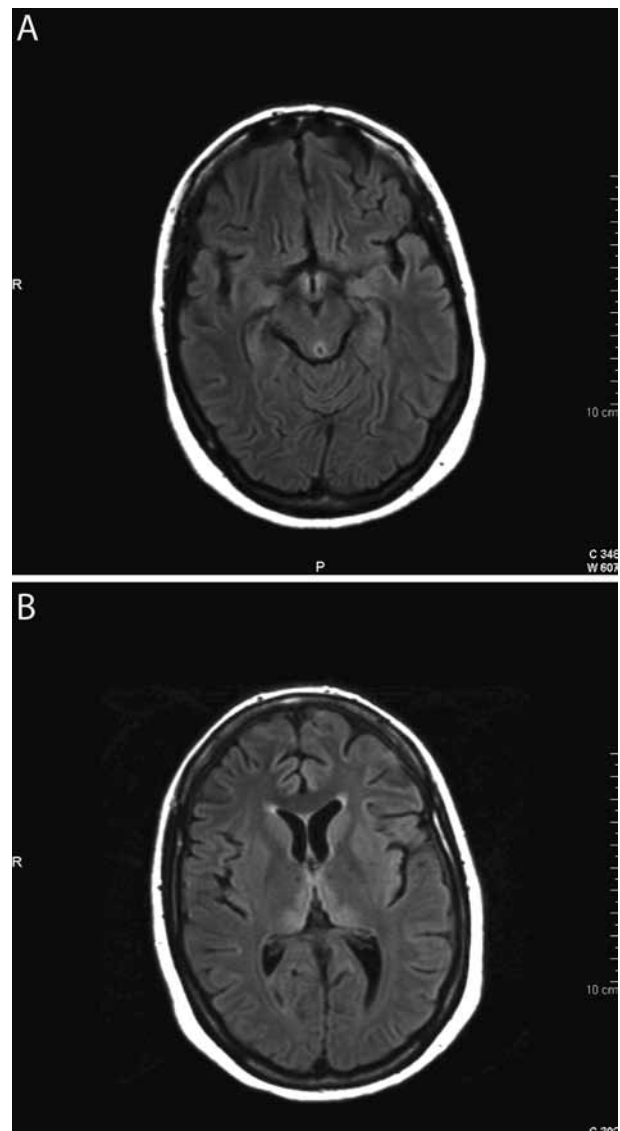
Brain MRI findings in patient 1
